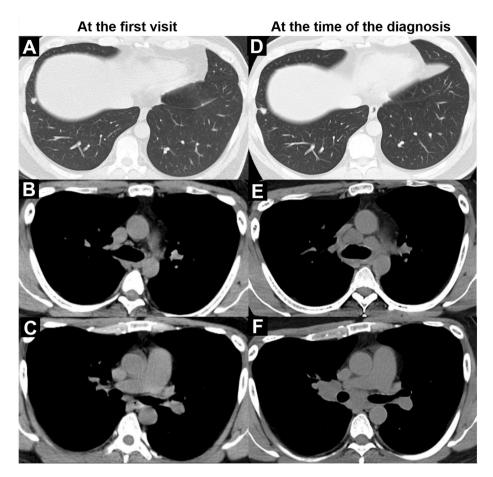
Findings of the chest computed tomography imaging during the patient's course: (A, B, and C) at the first visit and (D, E, and F) at the time of diagnosis; mediastinal/hilar lymph nodes had rapidly enlarged at 6 months.
